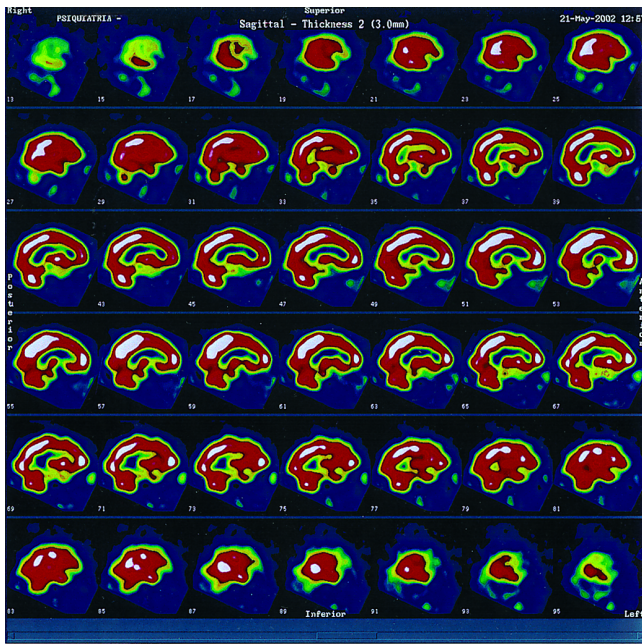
Baseline brain SPECT (with <sup>99</sup>Tc). Saggital cuts. Regional brain flow pattern and neuronal metabolic activity are normal.
